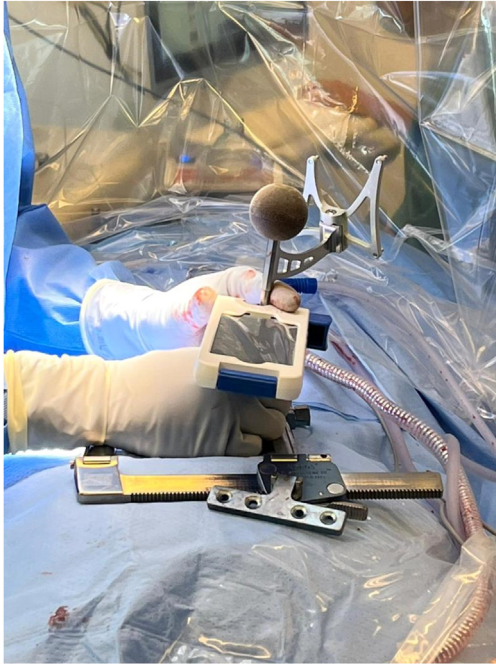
HND combined with CT-Nav guided navigation system set-up for study purposes.
